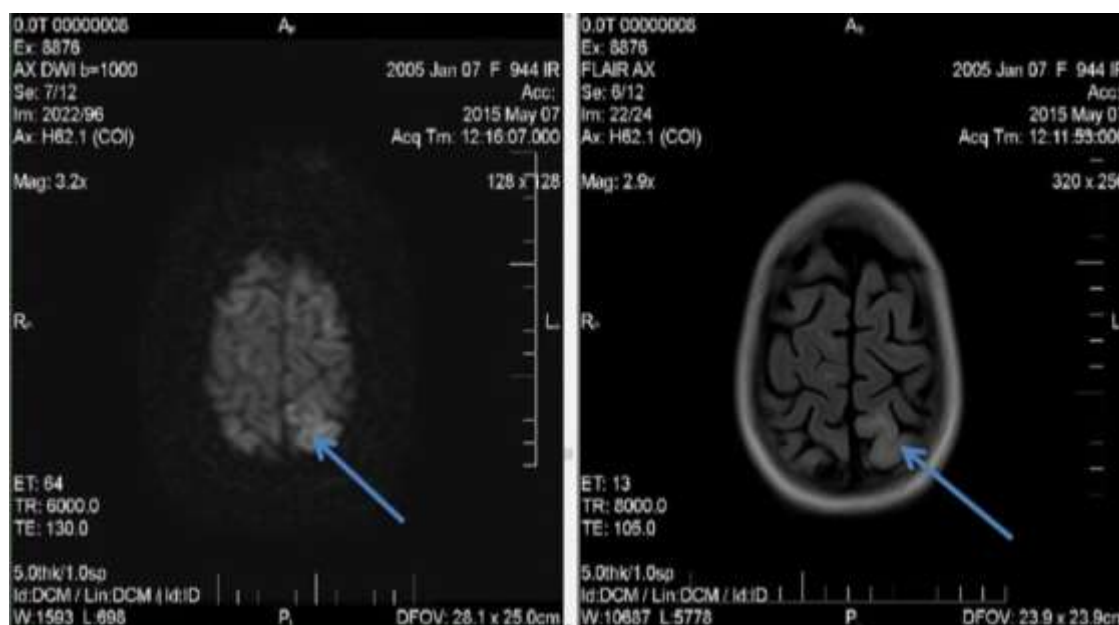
MRI diffusion and FLAIR: cortical hyperintensity in the parietal posterior lobe - white matter
